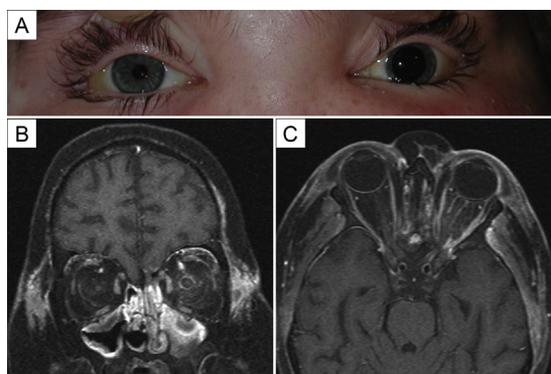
A, Clinical photograph of patient 6 on initial examination. B-C, T1-weighted MRI with gadolinium contrast, coronal (B) and axial (C) slices.
